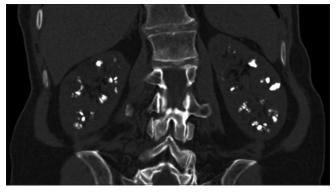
Abdomen computed tomography without contrast demonstrated numerous small bilateral nonobstructive renal calculi at papillary tips suggestive of medullary sponge kidneys
